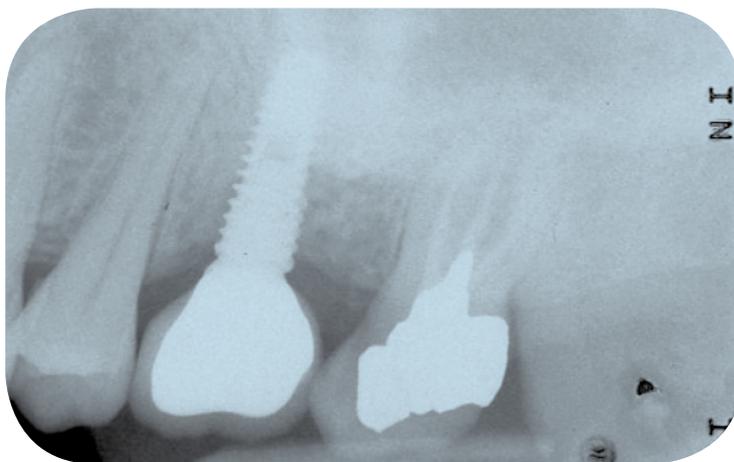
Peri-apical radiograph taken in April 2014
